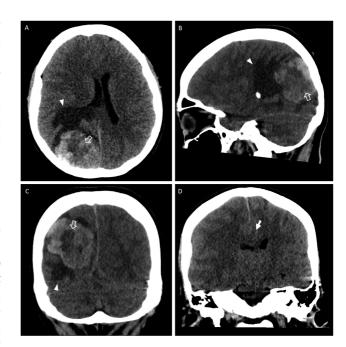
Noncontrast cranial computed tomography: (A) axial, (B) sagittal, and (C, D) coronal. The right occipitoparietal lobes show a supratentorial, intra-axial, corticosubcortical lesion with partially defined and lobulated margins. It is heterogeneous, predominantly hyperdense (64 UH), with a low-density center that could suggest necrosis (hollow arrows). Vasogenic perilesional edema was associated (arrowheads) with narrowing of adjacent sulcus, right displacement of the midline, and right subfalcine hernia (white arrow).
